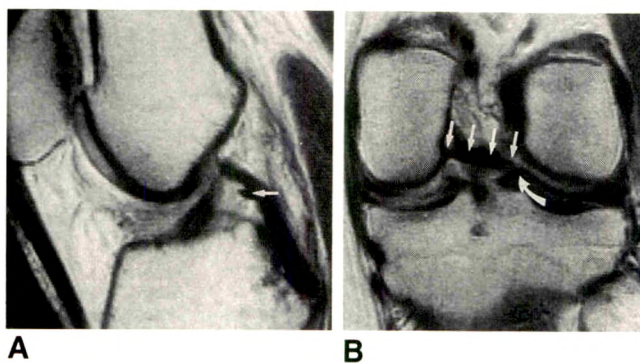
A and B, Sagittal (A) and coronal (B) T1-weighted MR images show course of meniscomemoral ligament of Humphry (straight arrows) arising from medial aspect of intercondylar notch and extending to posteromedial aspect of lateral meniscus (curved arrow).
